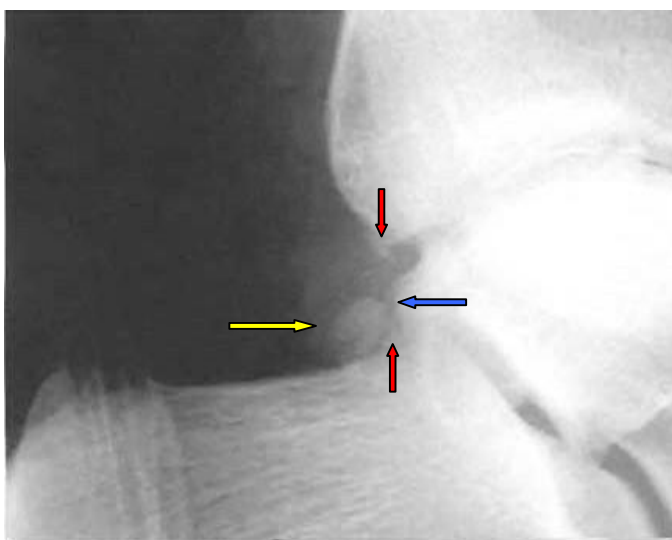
Figure # 28 (above). There is indeed a fracture demonstrated in the above radiograph. Can you spot it? The yellow arrow points to the os trigonum, a normal sesmoid seen in about 50% of the population. Some have postulated that the os trigonum represents an ununited apophysis of the posterior process of the talus. Note the smooth rounded edges typical of a sesmoid bone. Also note the ragged edge of the posterior process of the talus (blue arrow). This area is likely the origin of the two small avulsion fragments (red arrows) demonstrated in this patient with a Sheppard's fracture, i.e. a fracture of the lateral tubercle of the posterior process of the talus (also called the astragalus). Case courtesy of Wheelless Textbook of Orthopedics on line. [www.medmedia .com](http://www.medmedia.com)
